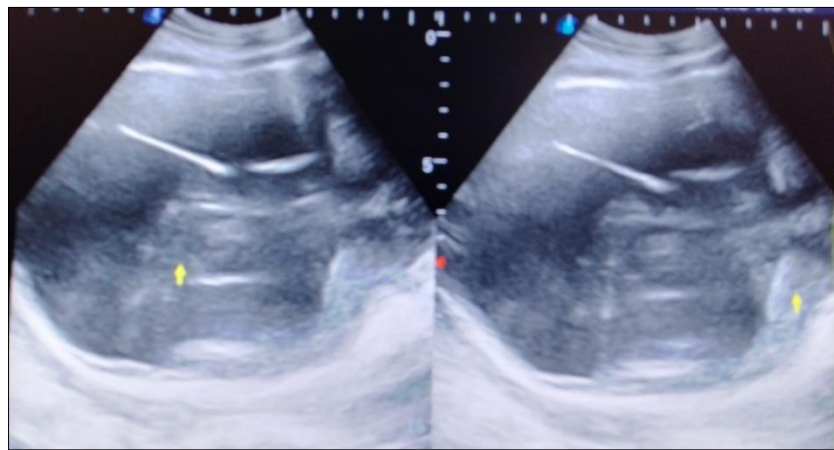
Both images are sonograms from TFUS through the anterior fontanelle, demonstrating absence of the cerebral hemispheres which are replaced by extensive amount of CSF, presence of an echogenic midline falx cerebri and the peripheral echogenic outline; the skull vault. The CSF replaced cerebral hemispheres is termed Hydranencephaly
